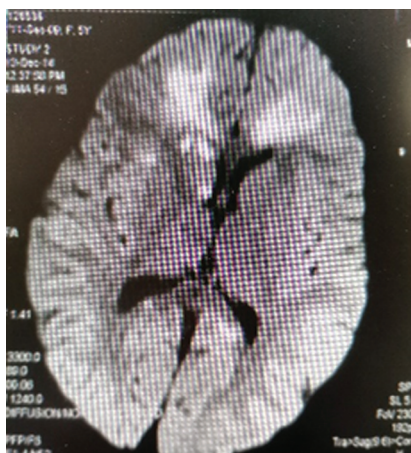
MRI of a child, 2,4 years old. The DWI shows multiple infarctions of the corpus callosum and the right caudate nucleus
